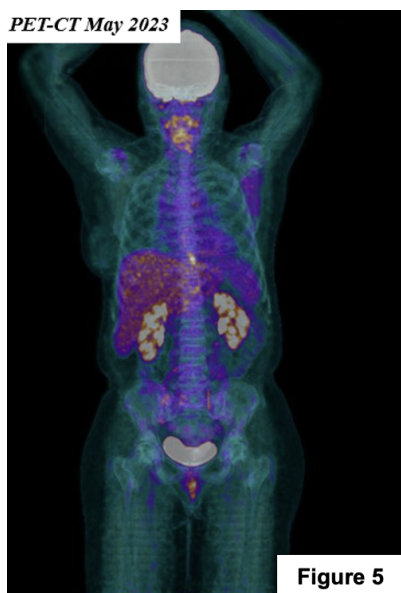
PET-CT demonstrated a significant partial metabolic response, with involution of the left axilla lymph node, in the mediastinal para-aortic and the left pulmonary hilum.
